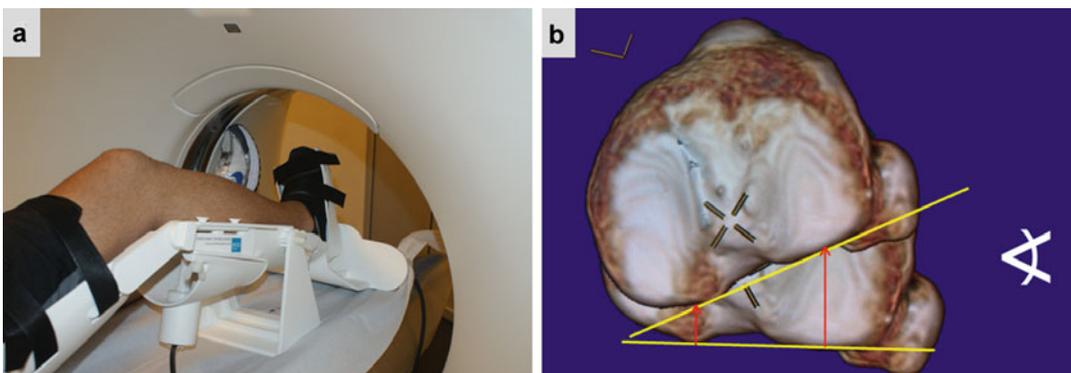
Porto-knee testing device (PKTD[®]) inside MRI equipment (a); CT 3D axial view representation of tibial internal rotation and anterior translation after load application by the PKTD (b)
